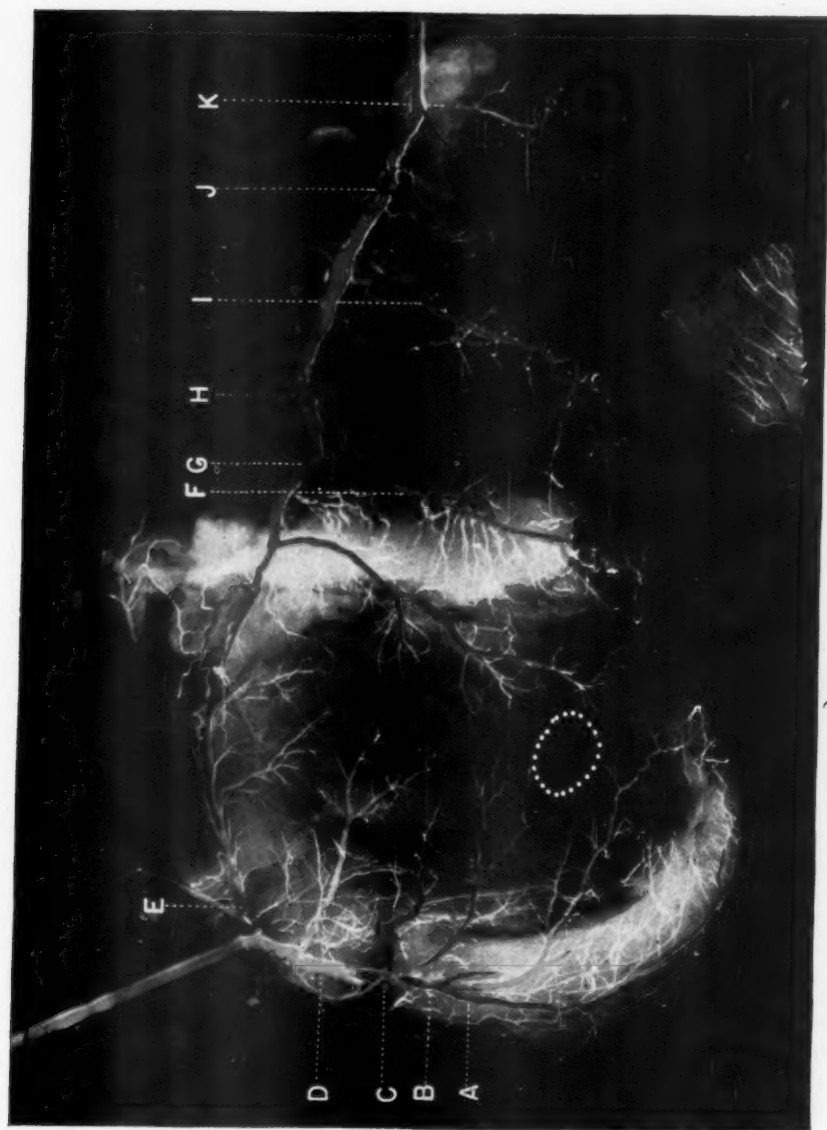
Copy of roentgenogram of injected and unrolled heart, with arteries tinted to indicate color identified by dissection.
